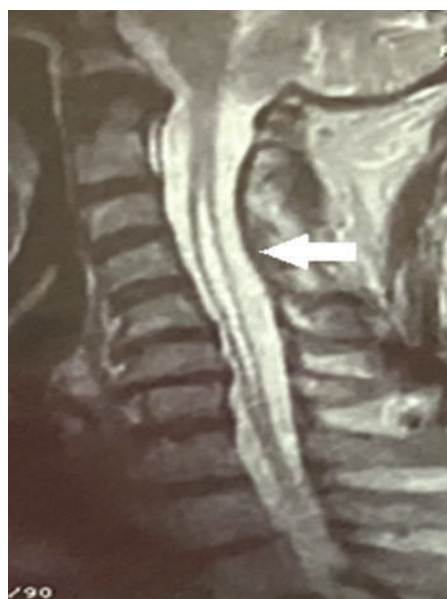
Magnetic resonance imaging (MRI) of the cervical spine in T2-weighted sequence, in sagittal section, showing extensive syringomyelic cavity extending from the C2 to the T3 level.
